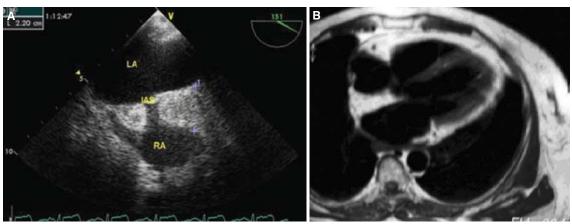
(A) Transesophageal echocardiographic view at the upper esophageal level and (B) cardiac magnetic resonance scan showing thickening of the interatrial septum. LA: Left atrium; IAS: Interatrial septum; RA: Right atrium.
